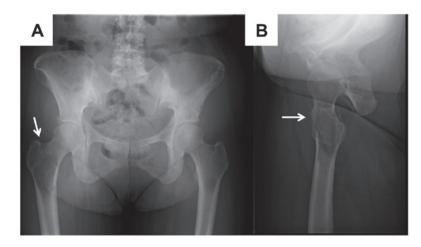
Initial hip X-ray image. Ill-defined osteolytic lesion and pathological fracture of the right femoral trochanter were detected. (A) Anteroposterior view; (B) lateral view. The white arrows indicate pathological fracture of femoral neck.
